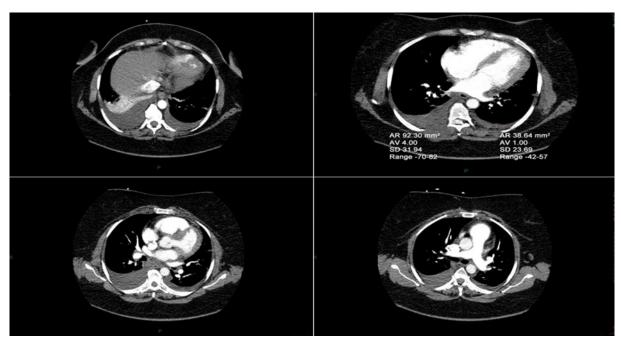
CT angiography showing bilateral pleural effusions - small on the left side and moderate on the right.
